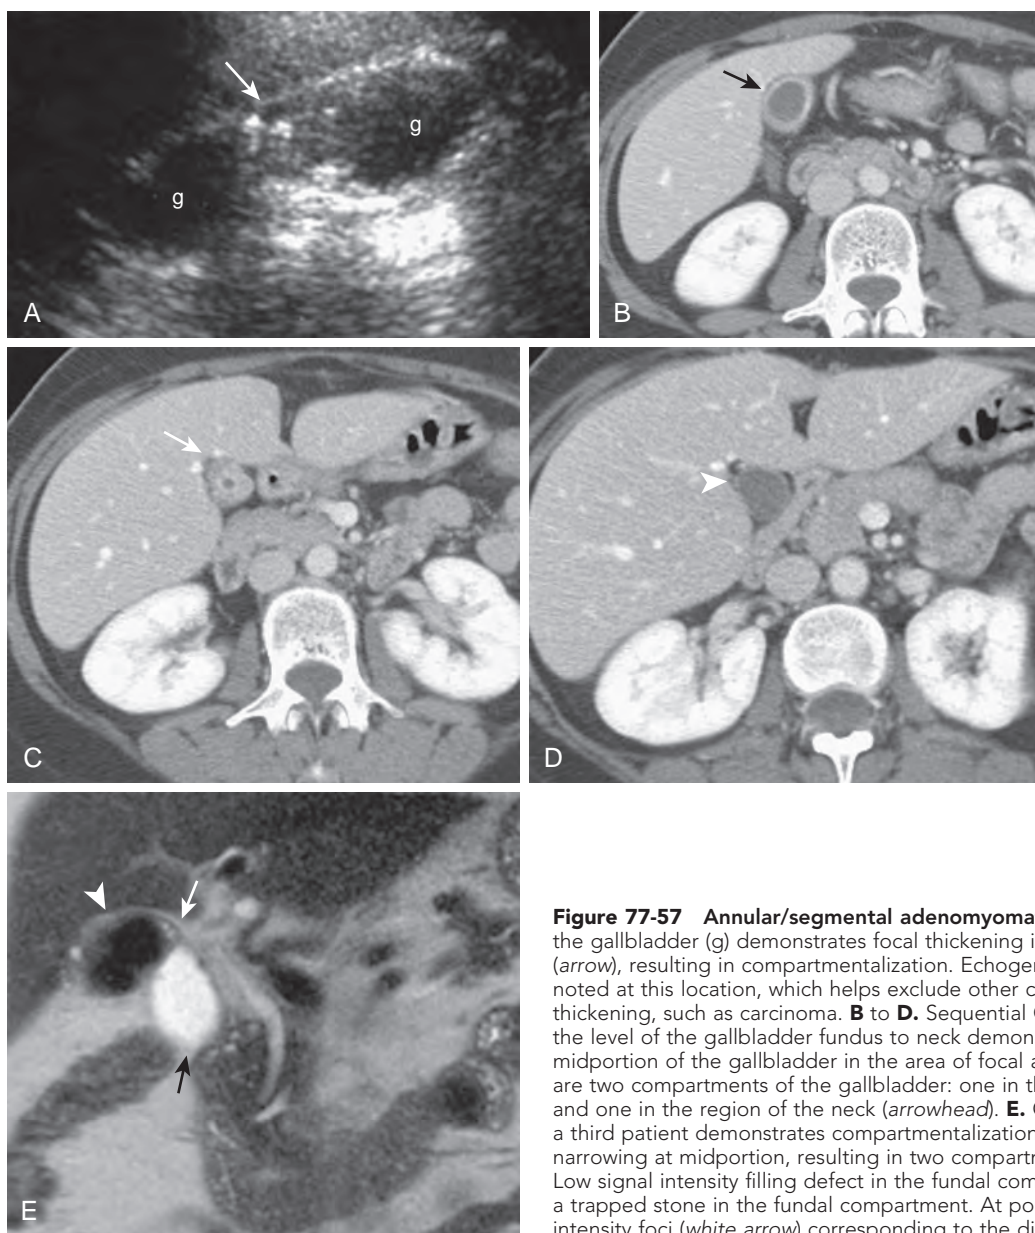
Annular/segmental adenomyomatosis. A. Sagittal ultrasound image of the gallbladder (g) demonstrates focal thickening in the midportion of the gallbladder (arrow), resulting in compartmentalization. Echogenic foci with ring-down artifact are noted at this location, which helps exclude other causes of focal gallbladder wall thickening, such as carcinoma. B to D. Sequential CT images in a second patient from the level of the gallbladder fundus to neck demonstrate focal mural thickening at the midportion of the gallbladder in the area of focal adenomyomatosis (white arrow). There are two compartments of the gallbladder: one in the region of the fundus (black arrow), and one in the region of the neck (arrowhead). E. Coronal T2-weighted HASTE image in a third patient demonstrates compartmentalization of the gallbladder with annular narrowing at midportion, resulting in two compartments (arrowhead and black arrow). Low signal intensity filling defect in the fundal compartment (arrowhead) corresponds to a trapped stone in the fundal compartment. At point of narrowing, there are high signal intensity foci (white arrow) corresponding to the dilated Rokitsky-Aschoff sinuses.
